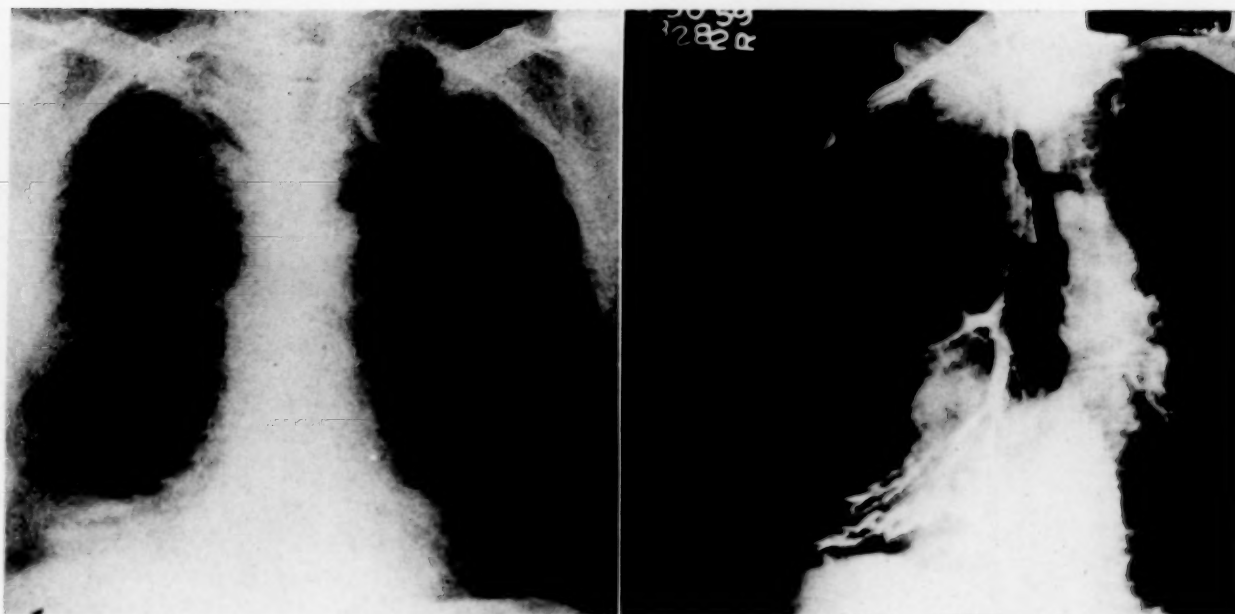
Case II. Postoperative chest roentgenogram and bronchogram showing disappearance of the empyema cavity and bronchographic evidence of bronchiectasis. Note crowding together of the bronchi in the middle and lower lobes of the right lung.
